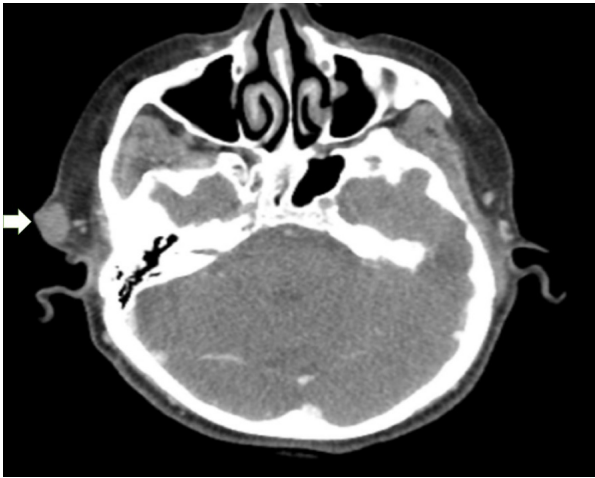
CT image of a 17x12mm contrast-enhancing solid mass lesion (White arrow) in the skin-subcutaneous fatty tissue at the right preauricular level.
